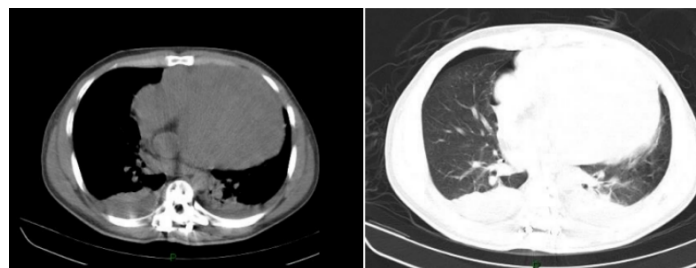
Computed tomography that allows the visualization of a voluminous mass in the region of the anterior mediastinum, compressing the adjacent posterior structures.
